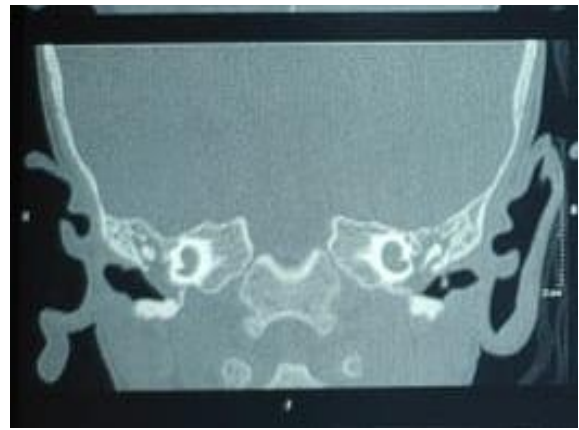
HRCT showing incomplete cochlea and cystic cochleovestibular malformation (original).
